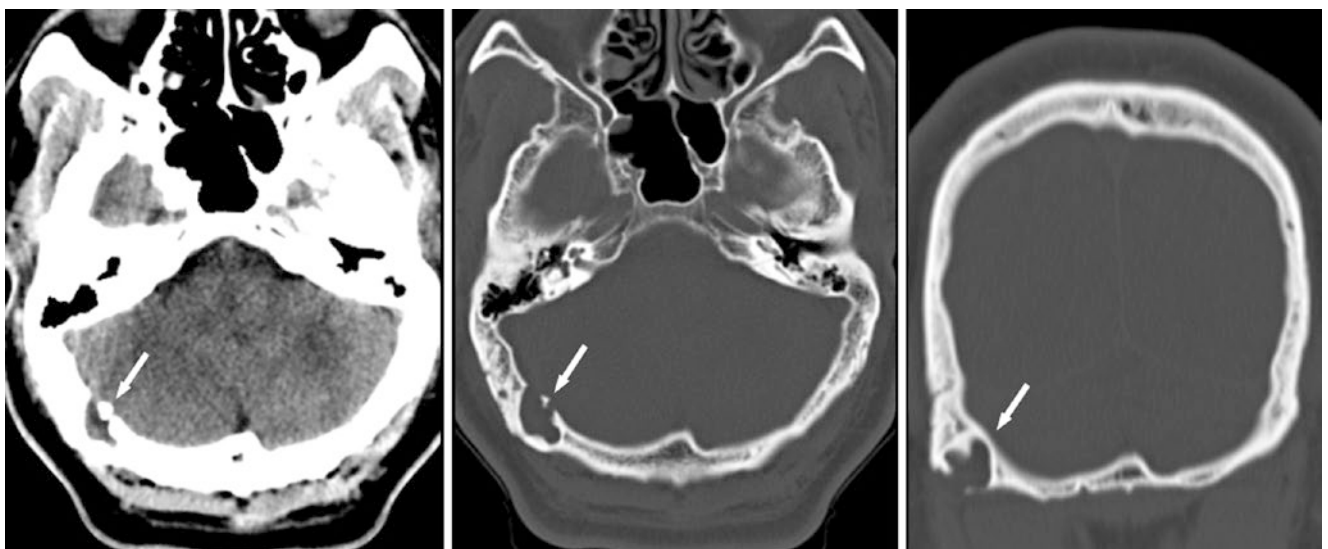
A 37 year old with trauma: a large (intra-) diploic vein (arrows) was noted on a CT with soft tissue (left) and bone (middle) windows. This channel connected the cranial vault to the upper cervical veins. Coronal reformats (right) show a sclerotic rim, confirming its benignity
